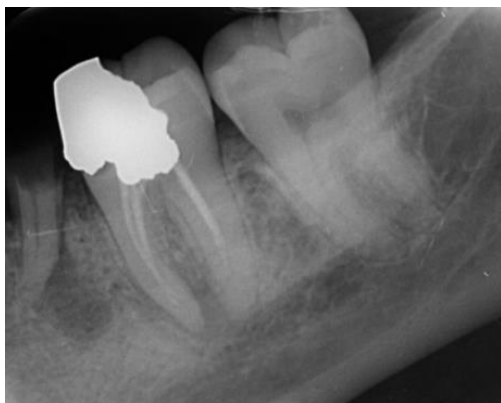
Initial periapical radiograph showing a radiographic lesion
